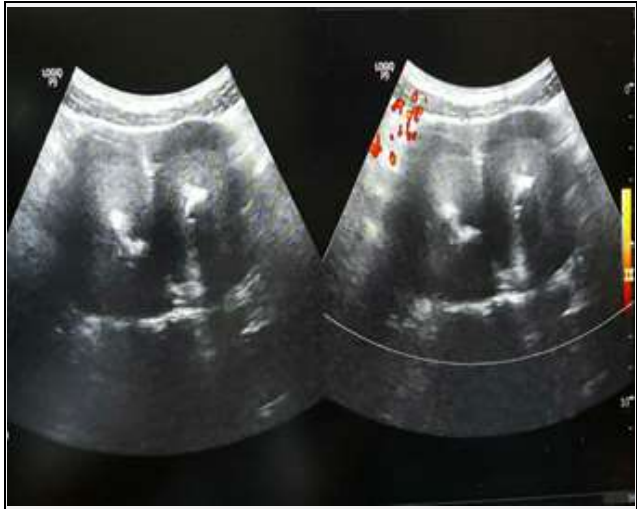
No Internal Vascularity Noted in Colour Doppler Study
